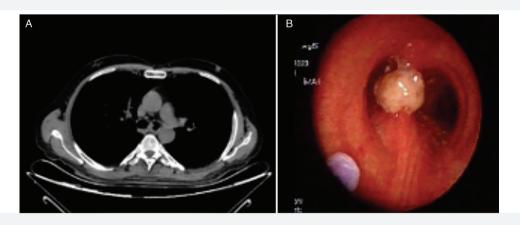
A) The tumor was observed on the level of carina in computed tomography. B) A mass on the carina was observed with fiberoptic bronchoscopy
